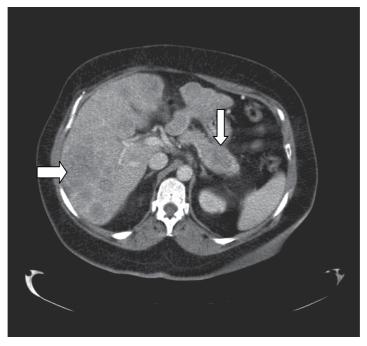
CT scan of malignant insulinoma (no contrast). Hypointense solid irregular mass of  $2 \times 3$  cm in the tail of the pancreatic gland. Hepatomegaly with multiple metastases, solid and hypointense, of different sizes, the bigger one of 5.5cm.
